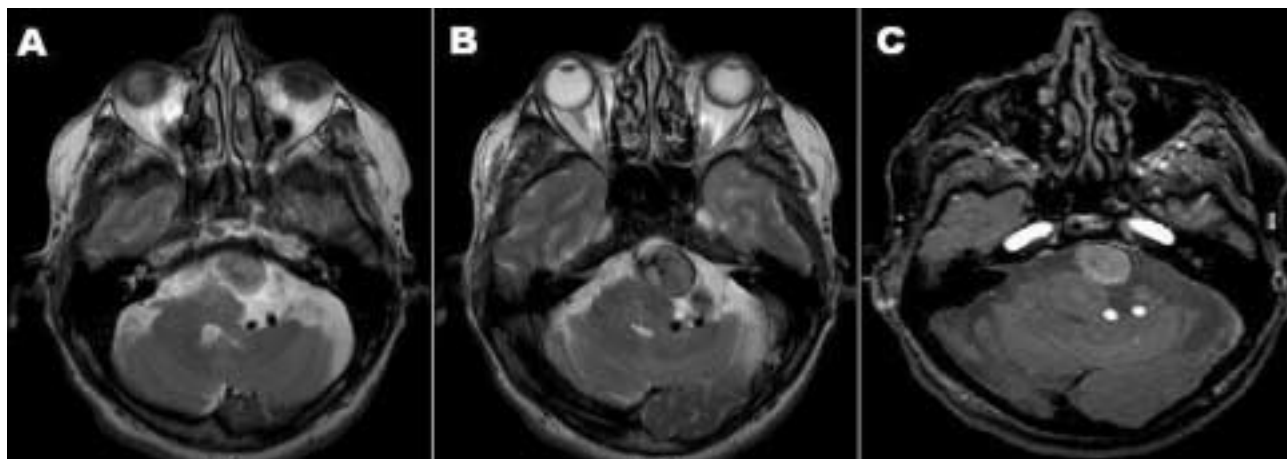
Axial T2-weighted imaging shows two tortuous dolichoectatic vertebral arteries compressing the root entry zone of 7-8th nerve complex and dolichoectatic fusiform basilar artery aneurysm with a mass effect on the brainstem and left cerebellar peduncle (A, B). On brain MR angiography, arteries are well depicted (C).
